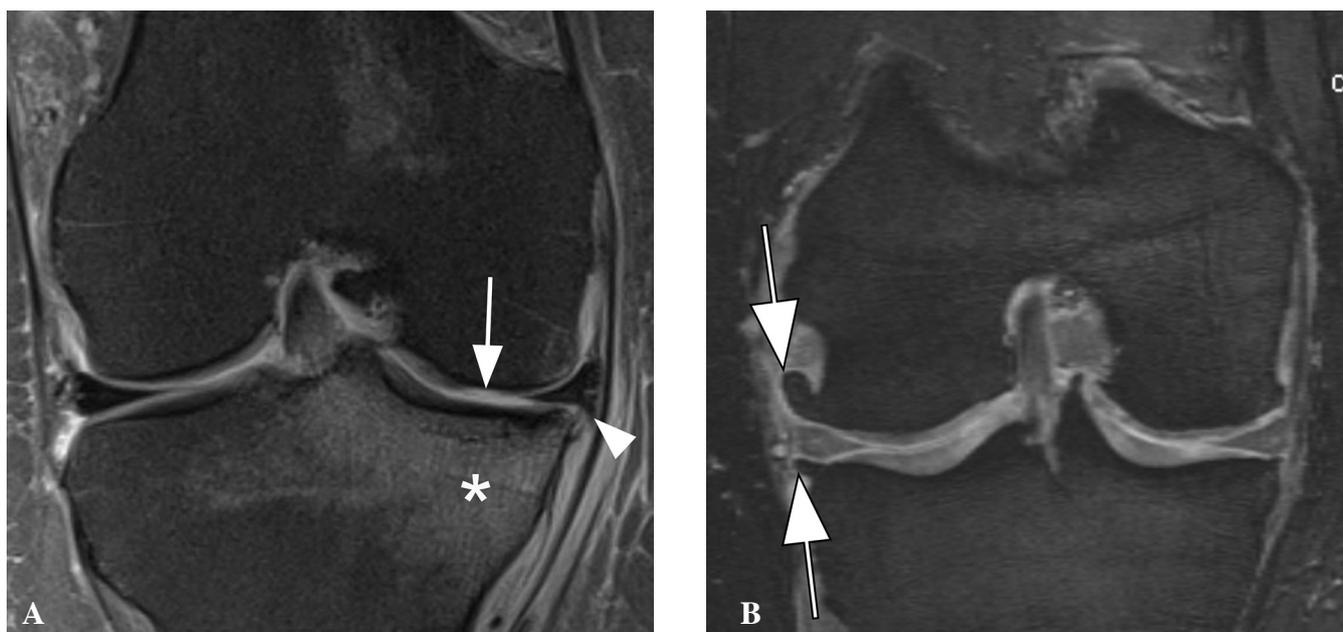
Additional structural phenotypes as defined by MRI.
